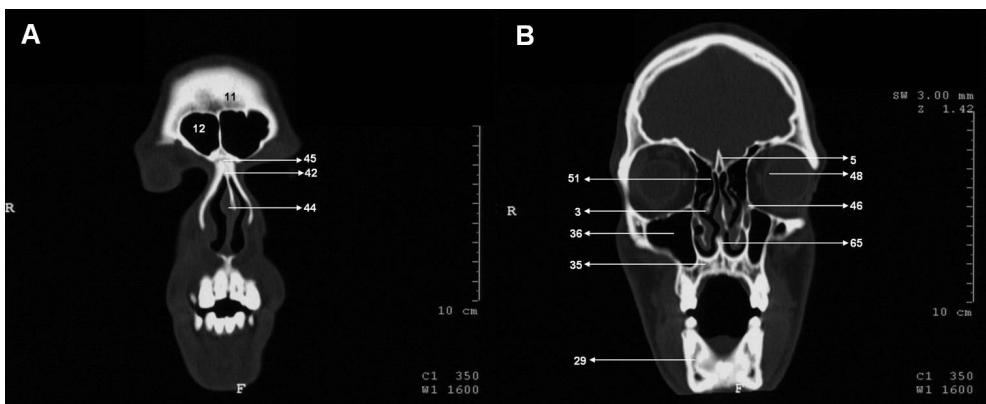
(A,B). Coronal CT anatomy of the facial skeleton; (C,D). Coronal CT anatomy of the facial skeleton; (E,F). Coronal CT anatomy of the facial skeleton
